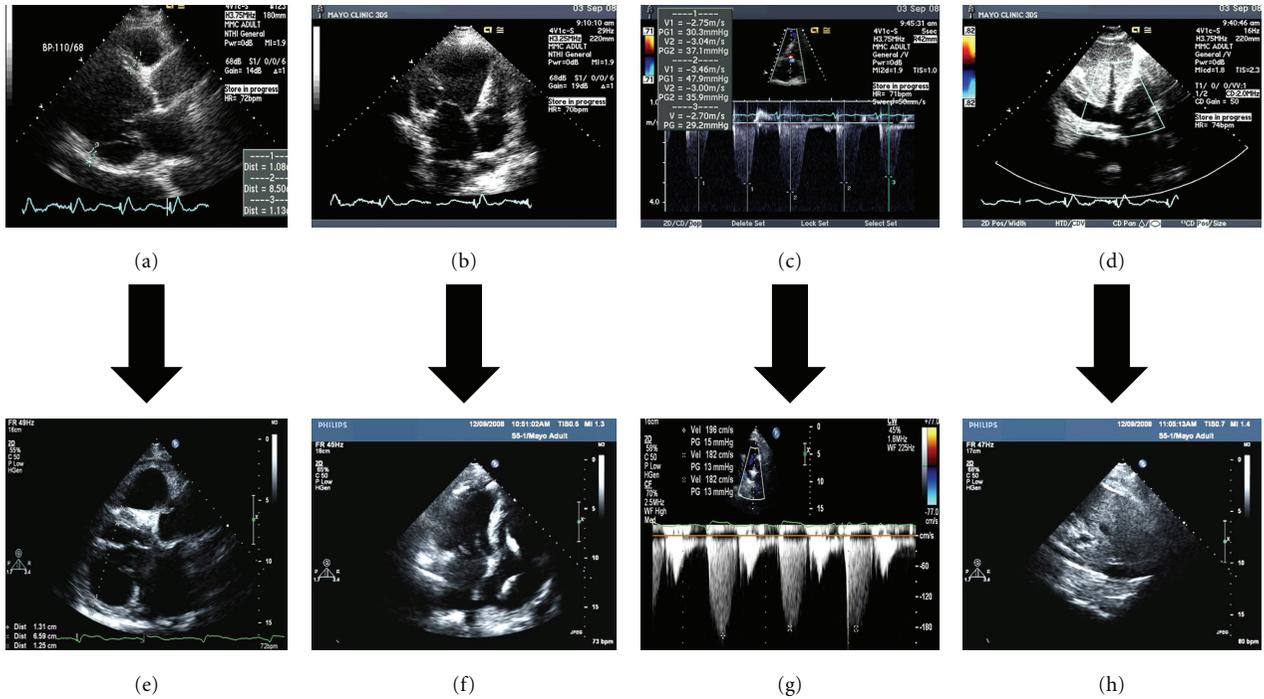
Interventricular dependency. Parasternal long axis view showing severely dilated LV (end-diastolic dimension 85 mm). (b) Apical 4-chamber view showing interventricular, interatrial septa shifted to the right, and increased tenting and annular dimensions of mitral valve apparatus. (c) and (d) Systolic right ventricular and right atrial pressure is increased. *The same patient two months after surgery.* (e) End-diastolic diameter decreased, and septal and posterior walls have thickened. (f) Interventricular and interatrial septa are now shifted to the left. Mitral annulus and tenting area have decreased as well as functional mitral regurgitation. (g) and (h) Systolic right ventricular and right atrial pressures have decreased significantly.
